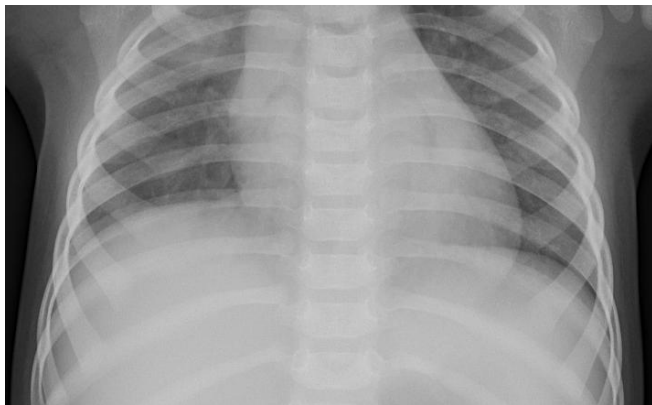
712 X 439 size chest x-ray
